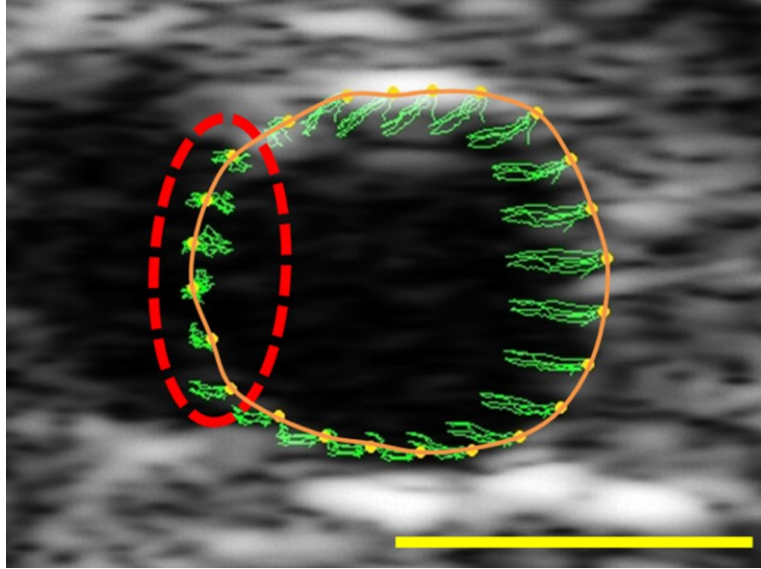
Sample ultrasound image of an aorta. Orange line indicates manually drawn spline. Green traces show the path of the tracking points (yellow) throughout several cardiac cycles. The dashed red line indicates a region that has poor contrast (likely due to a branching vessel) and therefore poor tracking. These regions were dropped from the analyses to improve accuracy. Yellow scale bar is 1-mm in length.
